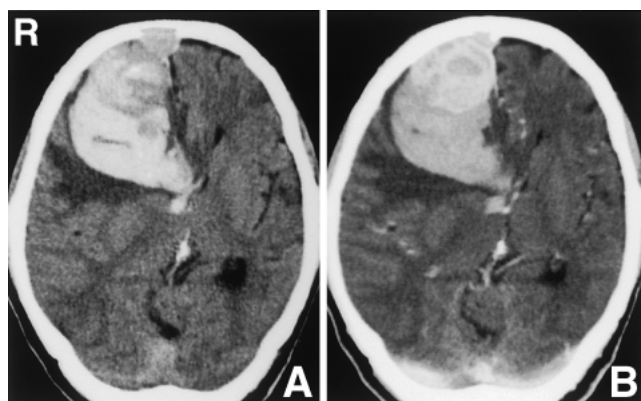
Case 1. Computed tomography scan showing a $5 \times 3 \times 5.5$ cm high density lesion in the right frontal parasagittal region (A), which was enhanced after injection of contrast medium (B), and massive hematoma in the brain tissue at the medial border of the lesion. Marked perifocal edema, midline shift, and bone defect of the internal table of the calvaria are also seen.
